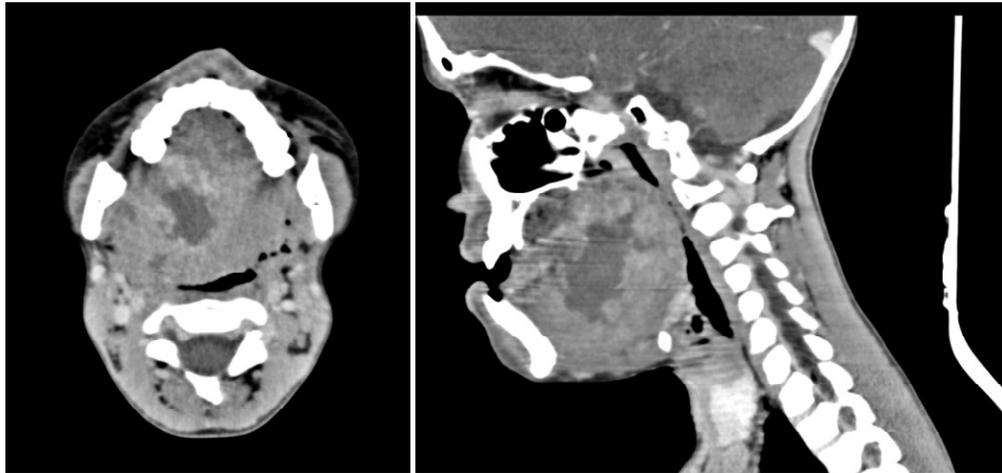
CT scan showing an endo-buccal tumor process locally infiltrating and completely obstructing the oropharyngeal lumen.
